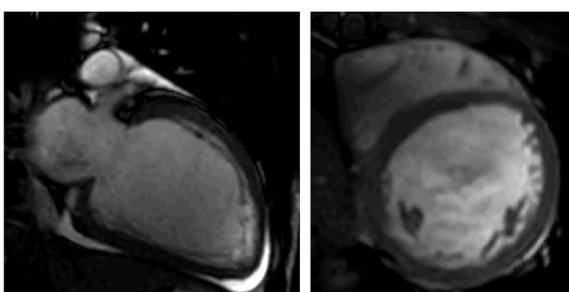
Clinical case report of a patient with frequent MA abuse. A: Chest X-ray showing cardiomegaly and lung congestion at the time of hospital admission. B: Transthoracic echocardiogram showing LV-dilatation and moderate to severe secondary mitral regurgitation due to ring dilatation. C: Diastolic 2 chamber and shortaxis views in cardiac MRI showing LV enlargement without signs of myocardial infarction or inflammation and discrete pericardial effusion.
